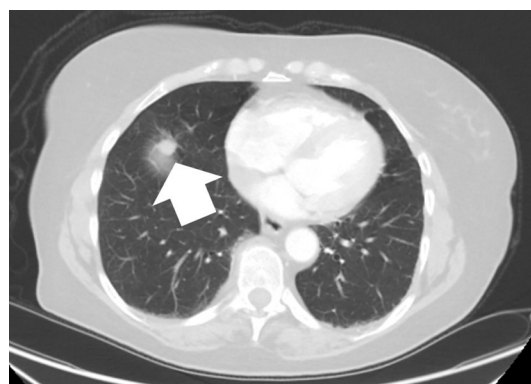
Radiological findings. The initial CT examination of the abdomen shows no pathologic findings; however, a mass appears near the diaphragm (white arrow).
